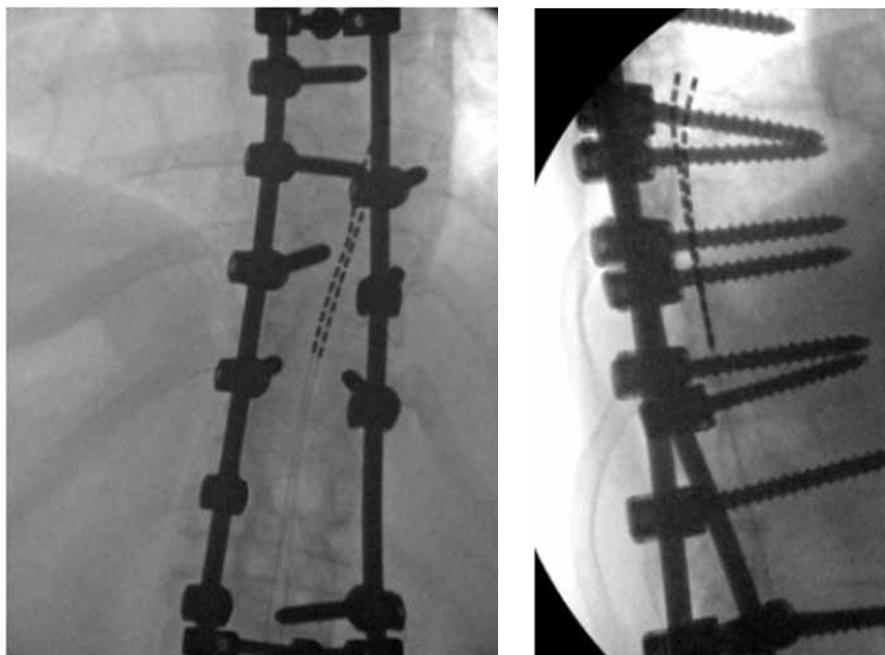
Final anteroposterior (left) and lateral (right) radiographs of spinal cord stimulator trial leads placed in a patient with congenital scoliosis status post T8-L4 fusion with Harrington rods.
